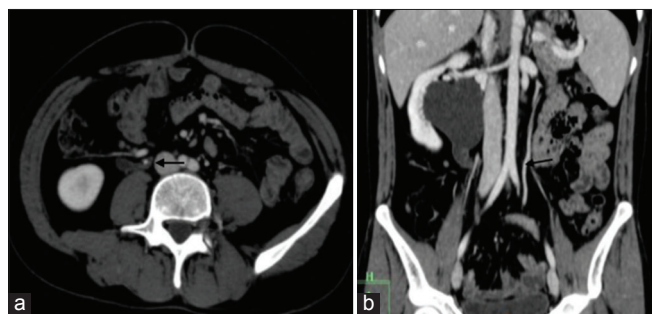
(a and b) Contrast-enhanced computed tomography (a - axial and b - coronal) showed an aberrant artery originating from the right renal artery, supplying the right psoas muscle, compressing the right ureter in its upper part (arrows), and causing gross proximal hydroureteronephrosis
